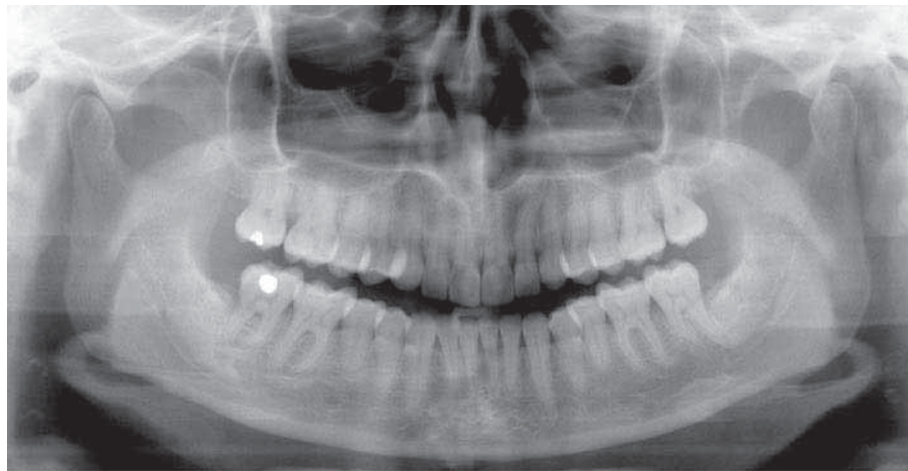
Radiograph of the Maxilla and Mandible. Plain Film with No Labels. For Labels, See Below (Fig. 640.2)
